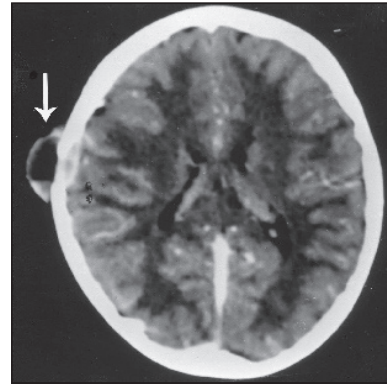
Brain CT with contrast showing a calvarial defect with bevelled edge, associated with an adjacent subgaleal soft tissue mass and fluid-fluid level.
